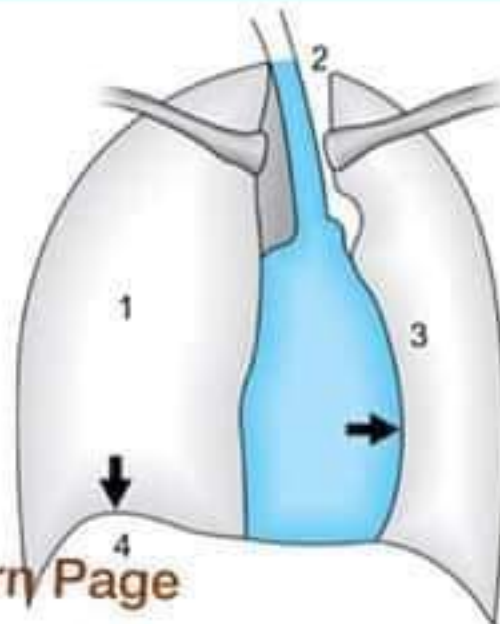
Chest X-ray showing massive lung collapse
